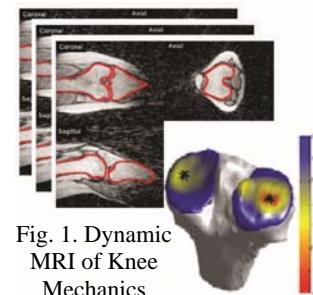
Dynamic MRI of Knee Mechanics
